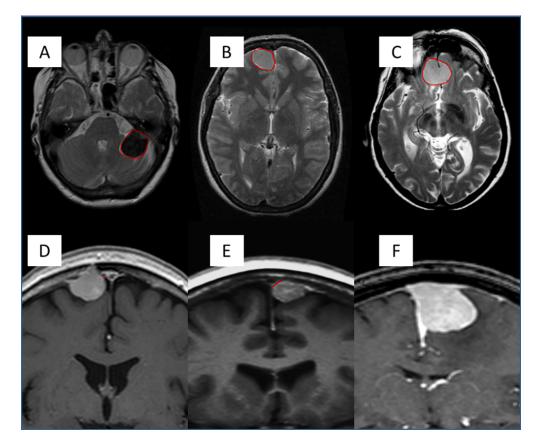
(A-C) T2 MR axial sequences showing the 3 levels of tumour intensity (circle). (A) Hypointense. (B) Isointense. (C) Hyperintense. (D-F) T1-weighted MR with gadolinium (contrast) showing the relationship between the meningioma and the nearby venous sinus (SSS). (D) Separate as there's no clear attachment to the sinus wall. (E) In direct contact with the lateral wall of the sinus. (F) Clear macroscopic distortion and invasion of the sinus.
